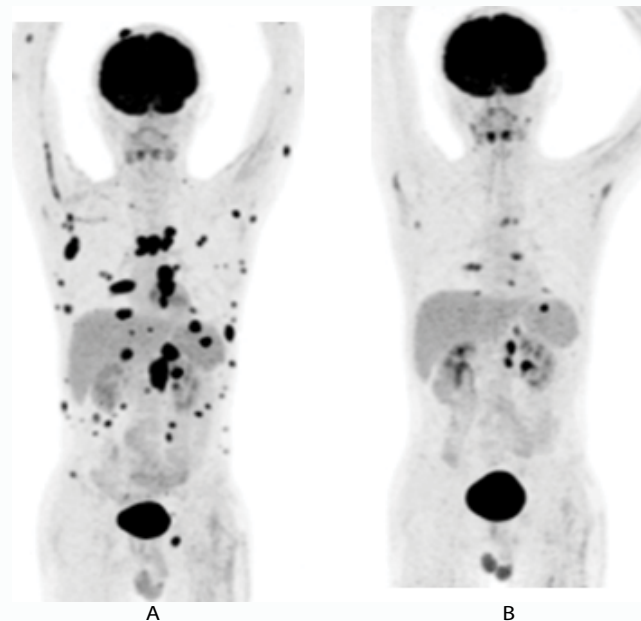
A) The patient's whole-body PET-CT image before the selinexor+GDP regimen showed that the lymphoma was involved in multiple systems. B) The patient's whole-body PET-CT image after first cycle of selinexor+GDP regimen showed that the lesions were significantly reduced, FDG metabolism was reduced, and the therapeutic efficacy was evaluated for PR.
